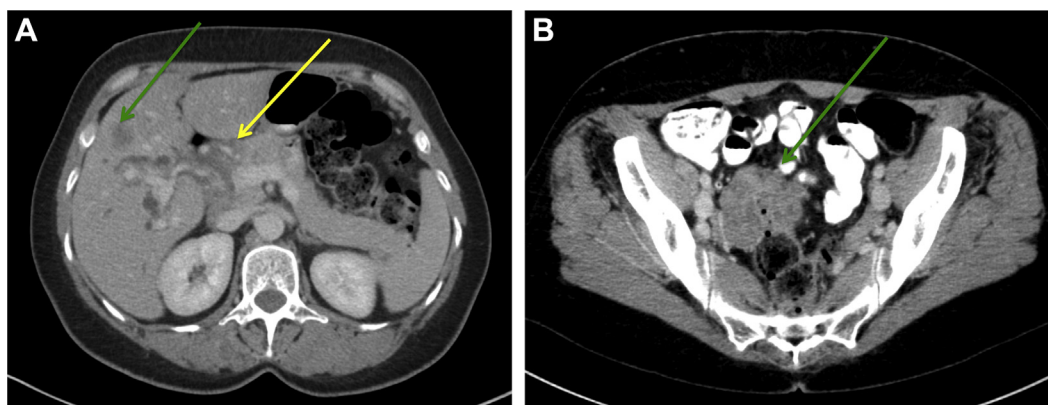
CT axial images of a pathologic lesion in the right lobe of the liver (green arrow), with biliary dilatation and a mass in the porta hepatis (yellow arrow) (A). An ill-defined mass is seen in the pelvic cavity on the right (green arrow) (B).
